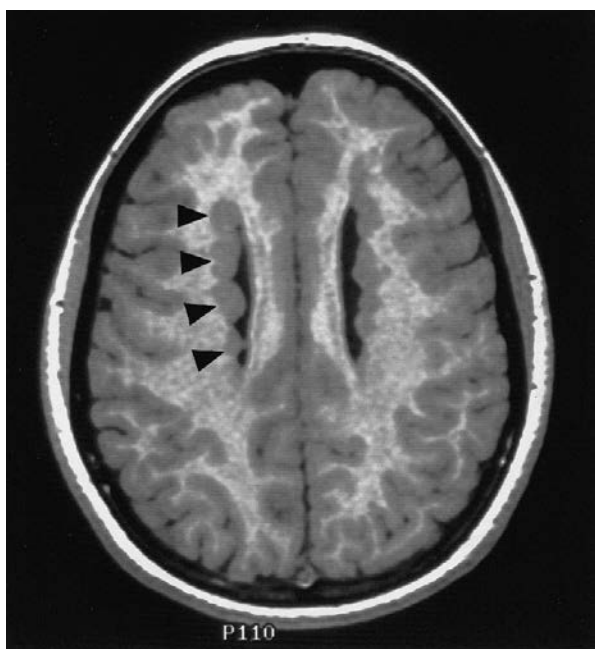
Periventricular heterotopia. Axial MRI image shows nodular masses of grey matter (arrowheads) lining the wall of the lateral ventricles. Note that the nodules have the same signal characteristics as the normal grey matter.
